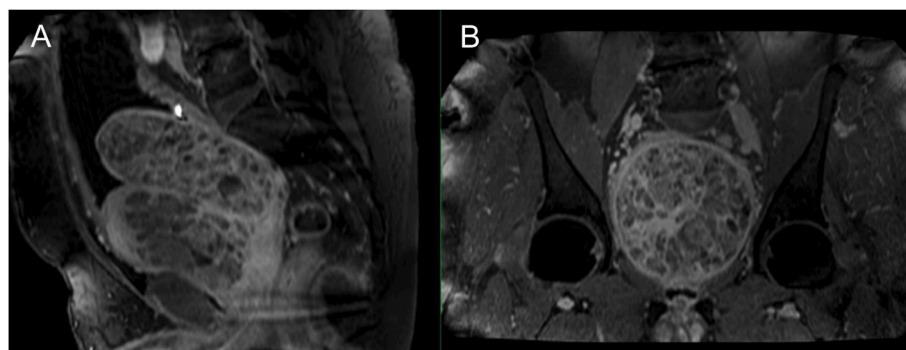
Preoperative MRI demonstrating a giant prostate A). Sagittal view B). Axial view.
